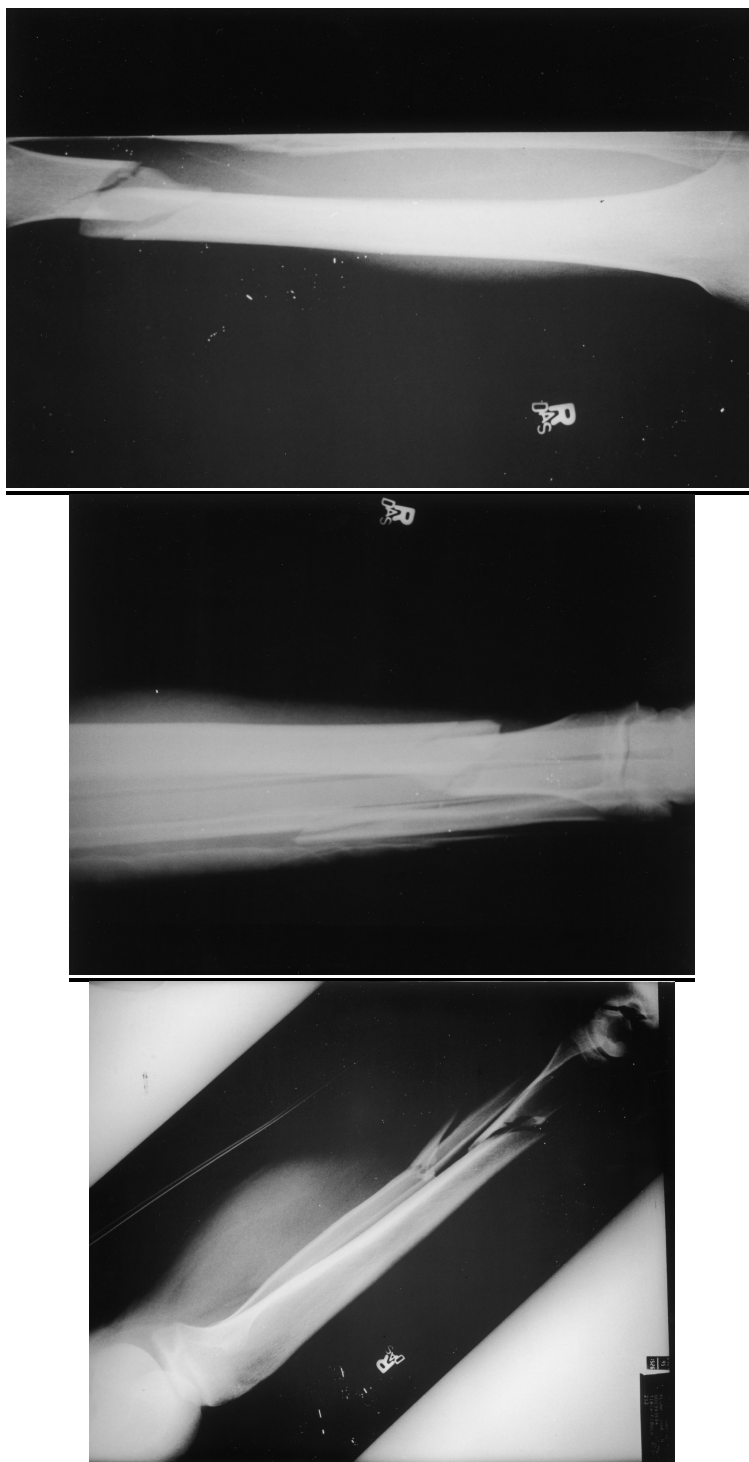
Radiographs from PWC File 17.
